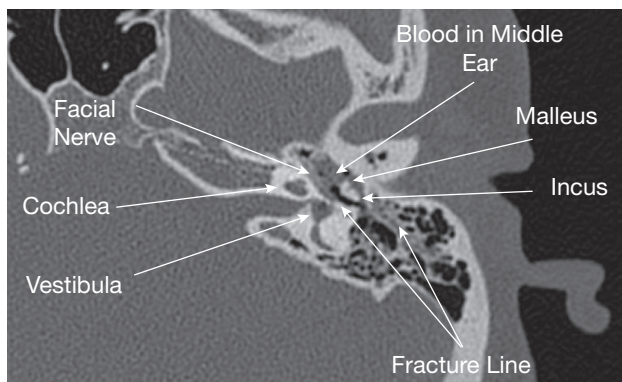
The axial CT scan of our patient's left temporal bone showed the fracture line as well as blood in the middle ear.
